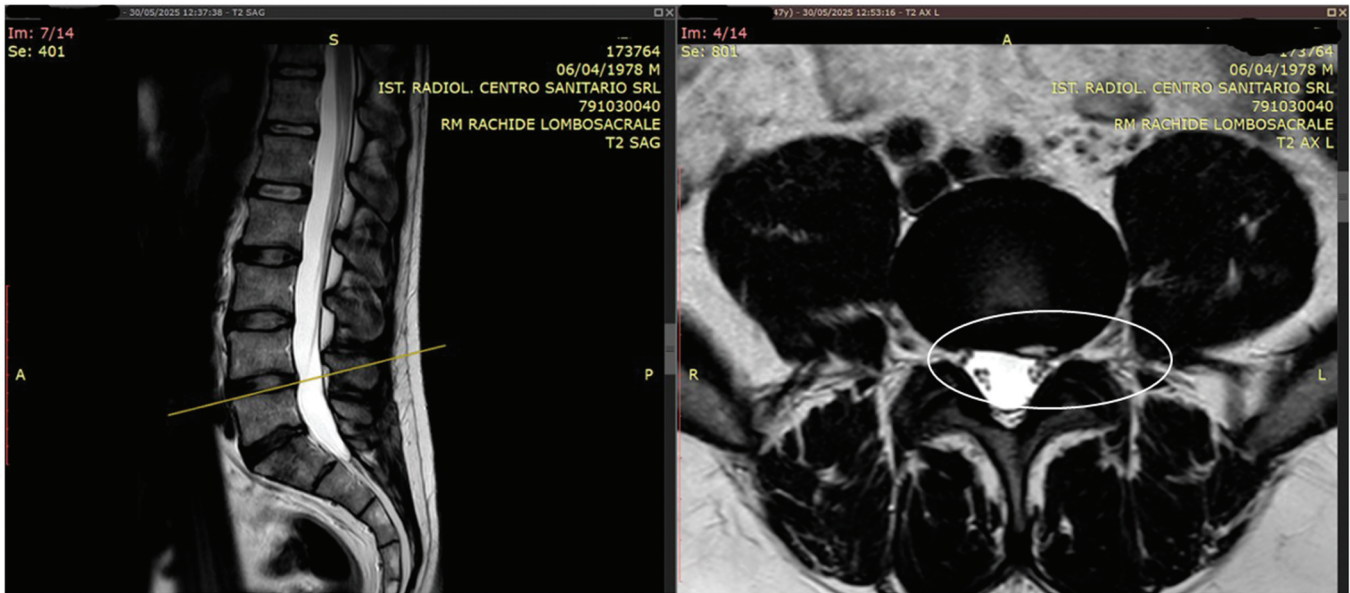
Magnetic resonance imaging (May 30, 2025) at follow-up. Lumbar spine revealed resorption of the L4/L5 disc extrusion (white circle).
